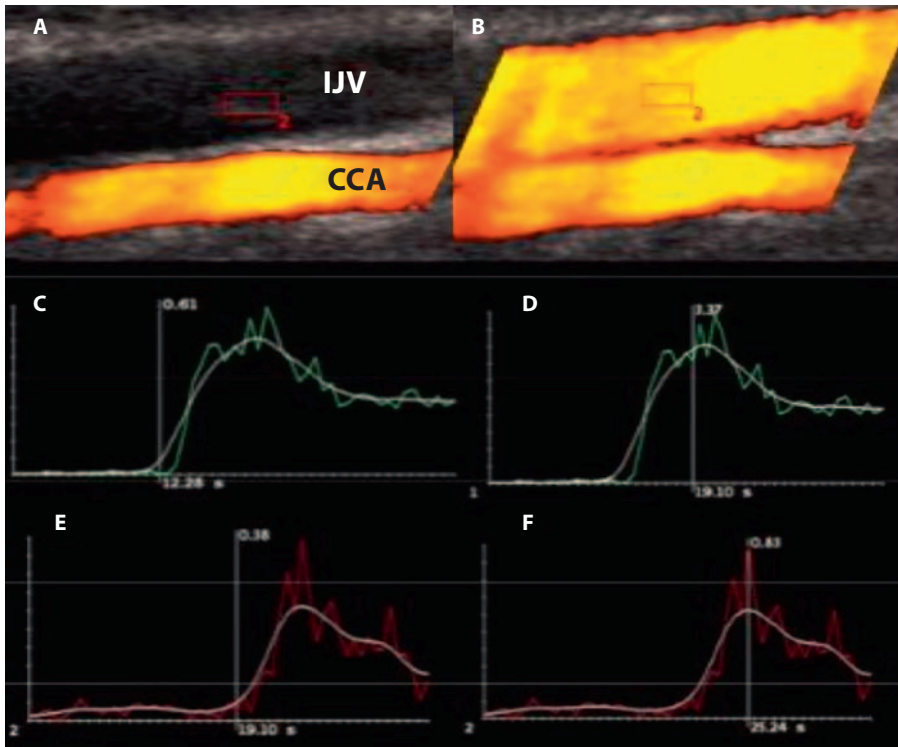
Measurement of cerebral hemodynamics using duplex sonography. Exemplary CTT and Δ TTP measurements using Axius ACQ® (Siemens, Elegra, Germany). Arrival of the contrast agent in the common carotid artery (CCA) after 12.3 s (A, C). The time to peak is reached after 19.1 s (D). Arrival of the contrast agent in the internal jugular vein (IJV) after 19.1 s (B, E) with a time to peak of 25.2 s (F). The CTT for this example is 6.8 s and the Δ TTP is 6.1 s.
